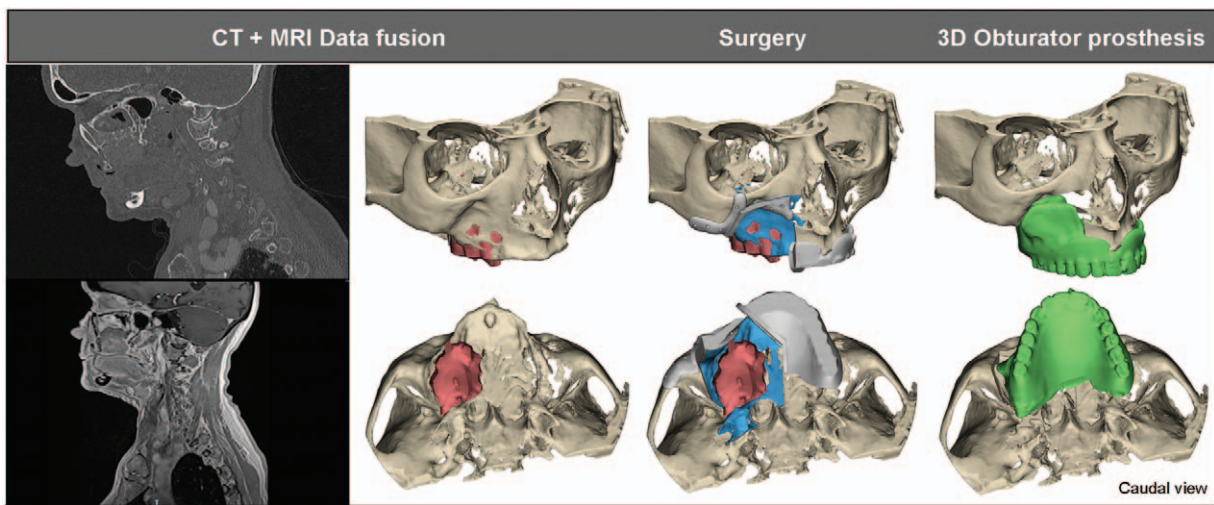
Tumour visualization based on CT and MRI data fusion. CT images are used for 3D reconstruction of bone tissue, whereas the MRI enables delineation of the tumour. This enables preoperative planning of the bone resection (blue) and thereby guide design (gray). Preoperative CAD/CAM manufactured obturator prosthesis (green) designed to obturate the defect following guided resection.
